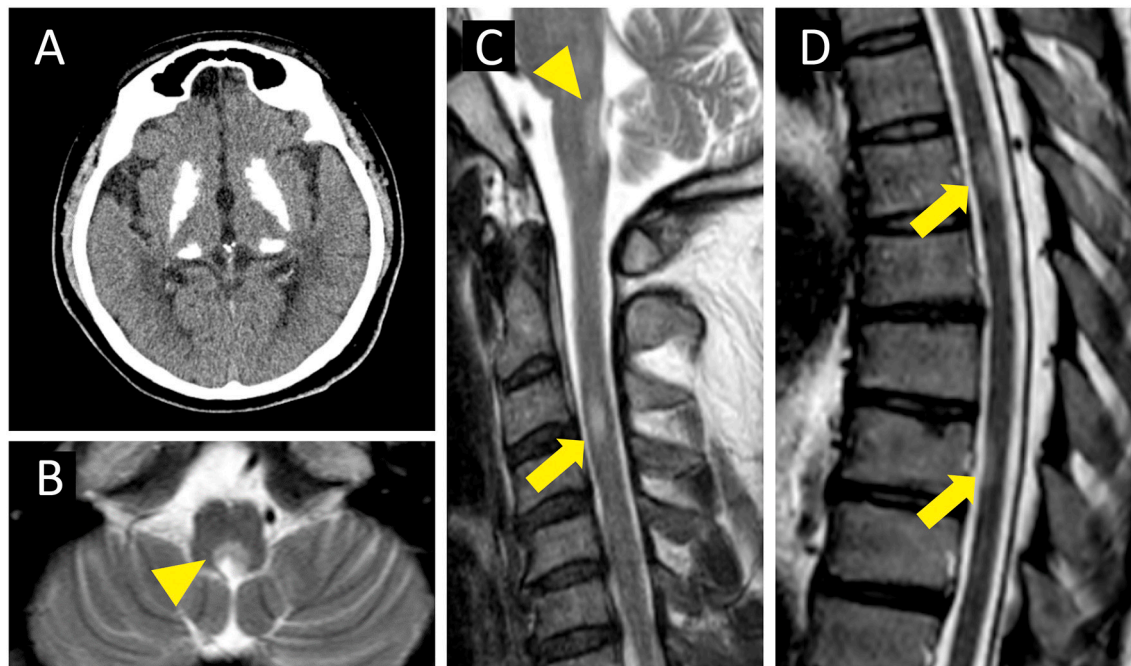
Findings of head CT and MRI and spinal cord MRI.
